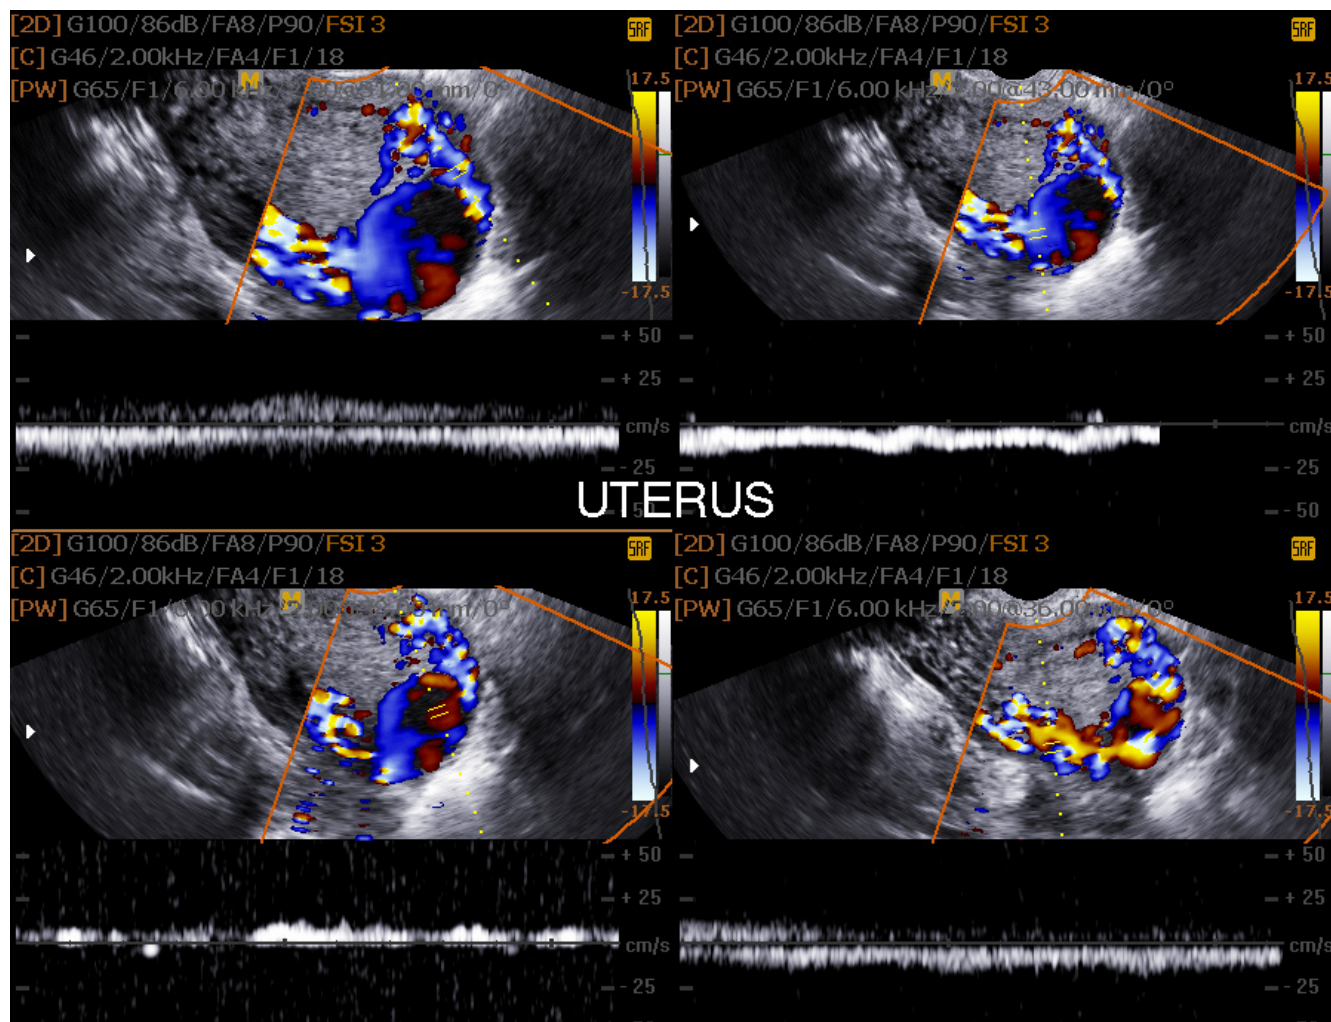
Transvaginal CD sonography showing large fundus myometrium cyst with bidirectional venous flow inside revealed by pulsed Doppler and color Doppler study suggesting large venous pseudoaneurysm
